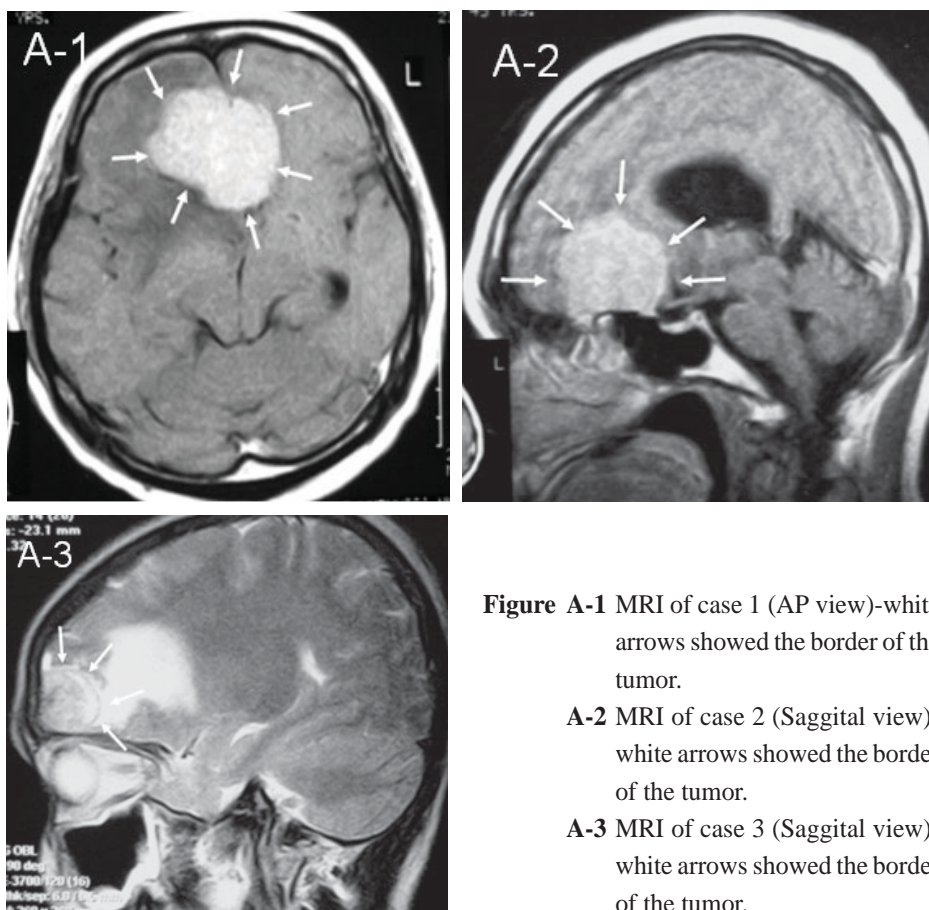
Figure A-1 MRI of case 1 (AP view)-white arrows showed the border of the tumor.
